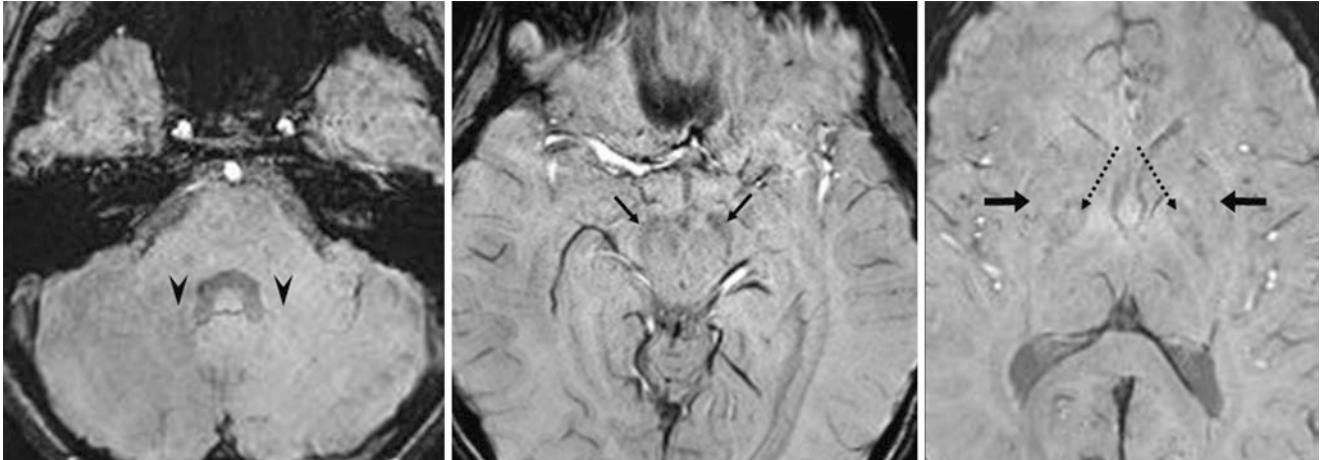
A 10 year old who underwent an otherwise negative 3T MRI for a middle ear mass. Axial SWIs show no visible iron deposition in the dentate nuclei (*arrowheads*), while there is very early deposition within the SN (*thin arrows*) and GP (*dotted arrows*) but not the putamen (*arrows*)
